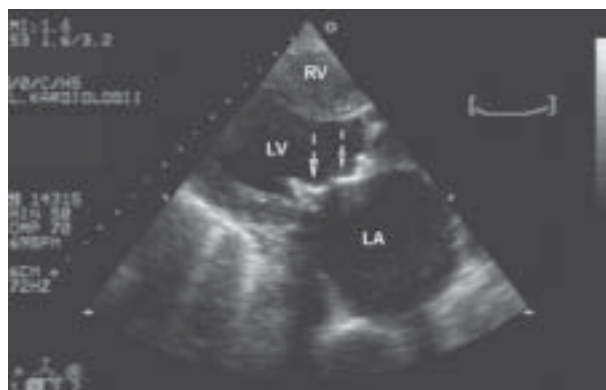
B-mode, modified, parasternal long axis view. Significant degeneration of the mitral bioprosthesis (calcified leaflets — arrows) and enlarged left atrium (LA); LV — left ventricle; RV — right ventricle
